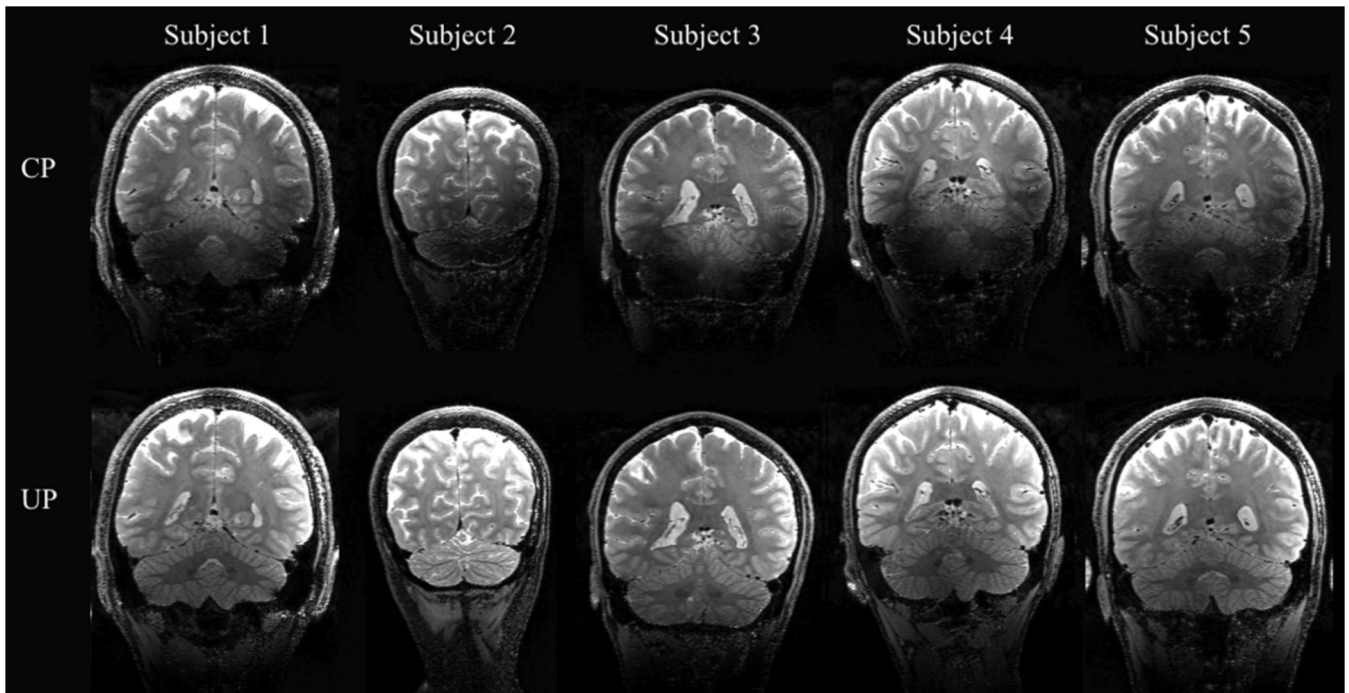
Circularly polarized (top row) and universal kt-points (bottom row) excitation and refocusing pulses applied to 3D T2-weighted imaging of the human brain at 7 T. Reproduced from [165].
